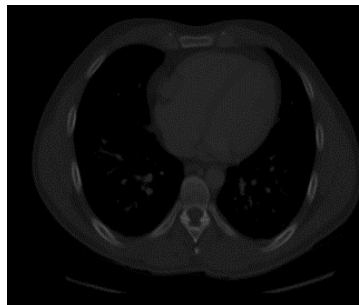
Low contrast CT image [8]
